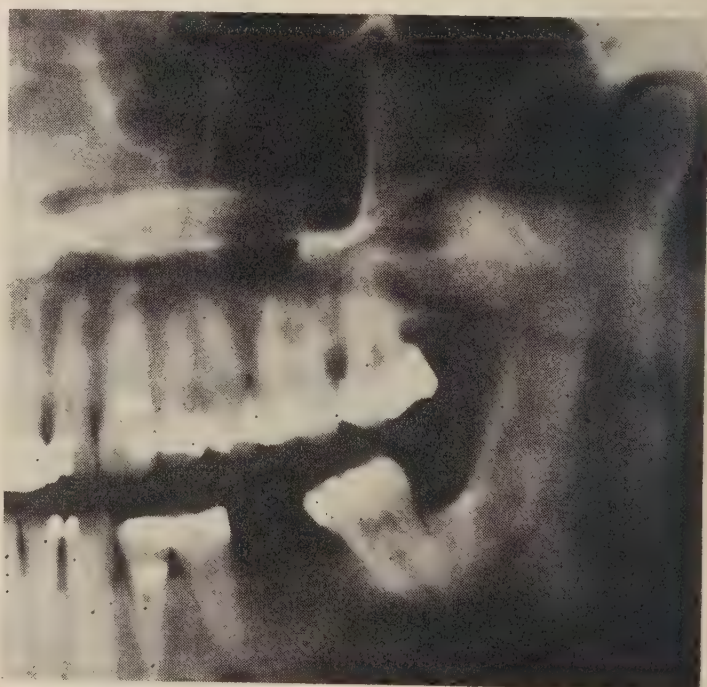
Panoramic radiograph (January 20, 1969) shows complete bony regeneration at two extraction sites. The original radiograph also showed new bone formation at the inferior border of the mandible.
